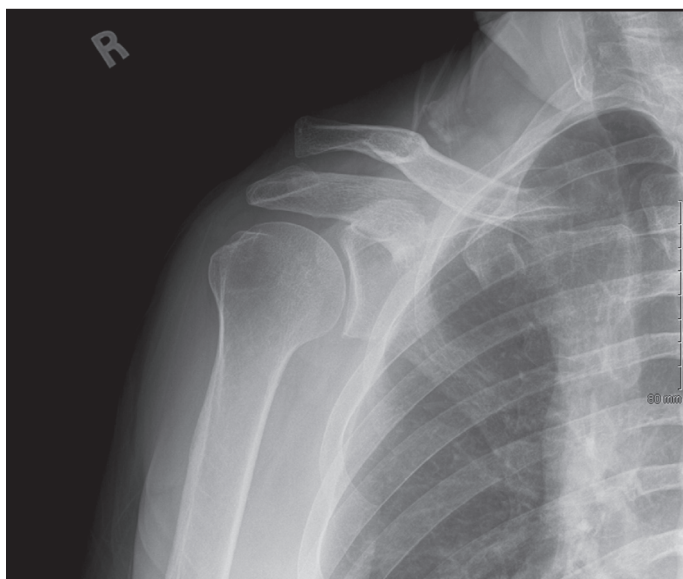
Antero-posterior view radiograph of the subject's right shoulder. Disruption of the acromioclavicular joint is the obvious finding.
